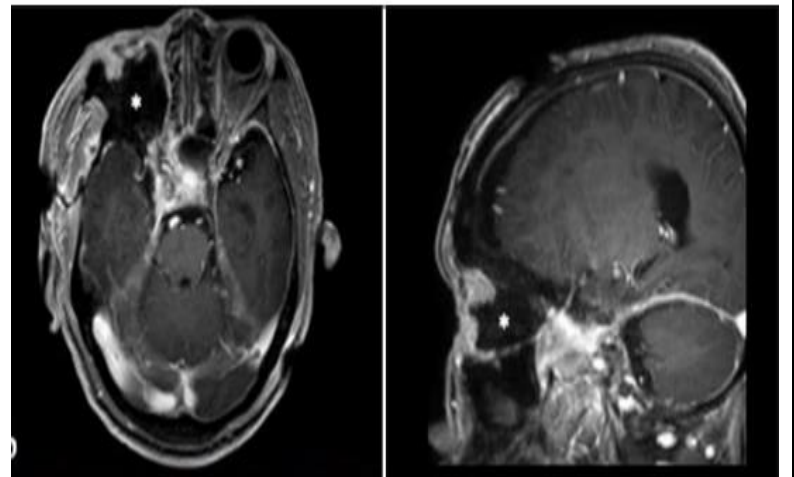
On improved T1-weighted images (left: axial, right: sagittal), all tumors were removed except those in the cavernous sinus. However, CSF retention was observed in the orbit (asterisk).
